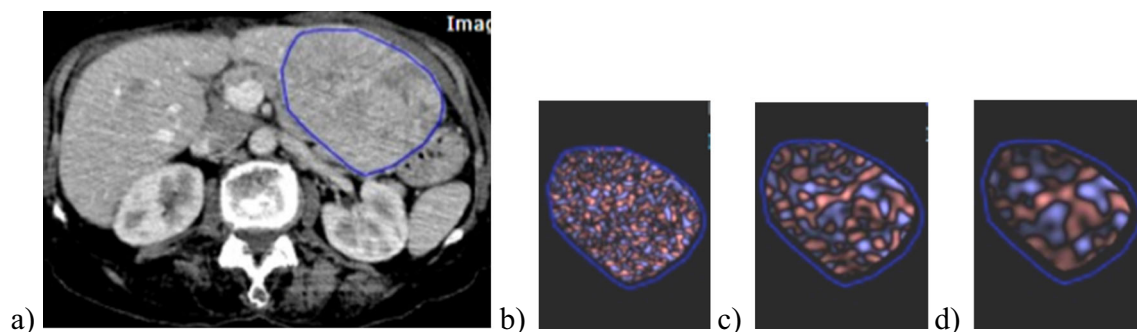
a Axial portal-venous phase contrast-enhanced CT image of an HCC in the left liver lobe with delineated region of interest. Corresponding texture images selectively display (b) fine (SSF = 2), (c) medium (SSF = 4) and (d) coarse (SSF = 6) textures of the lesion
